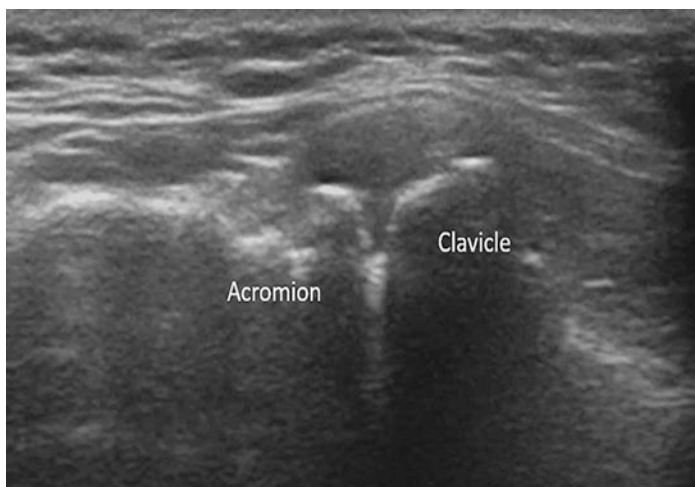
Ultrasound scan revealing superficial osteophytes, joint-space narrowing, and capsular hypertrophy [10]
